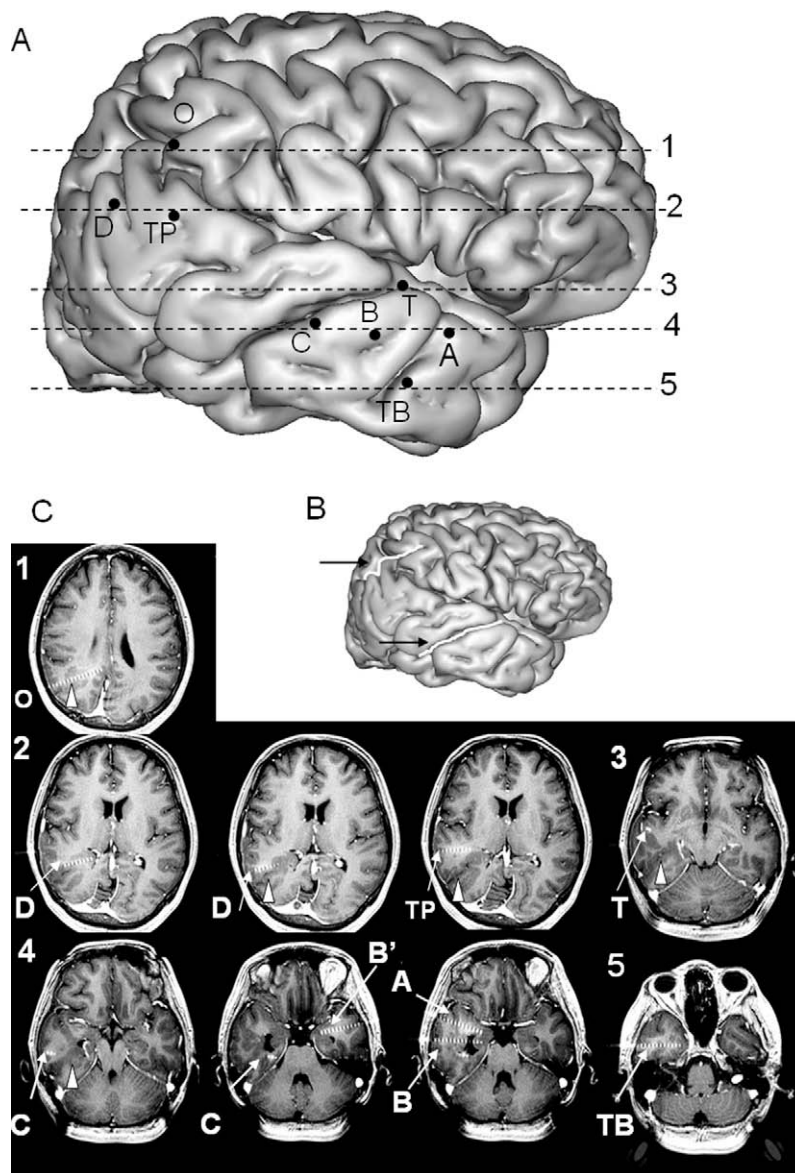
(A) Depth electrodes scheme superimposed on the 3D surface reconstruction of the patient's cranial MRI (right lateral view). (B) Same lateral view highlighting (white) the schizencephaly (black arrow). (C) Axial slices showing the electrodes trajectories (white arrows) and their position relative to the schizencephaly (white arrow heads). Electrodes placement was the following: in the right hemisphere, electrode A explored the amygdala and the middle temporal gyrus; B explored the anterior hippocampus; anterior schizencephaly and middle temporal gyrus; C explored the posterior hippocampus, anterior schizencephaly and middle temporal gyrus; TB explored the ento-rhinal cortex and the inferior temporal gyrus; T explored the anterior part of the superior temporal gyrus and sulcus; TP explored the posterior schizencephaly and superior temporal gyrus; D explored the posterior schizencephaly; O explored the posterior cingulate gyrus and posterior schizencephaly. In the left hemisphere, B' explored the anterior hippocampus and middle temporal gyrus.
